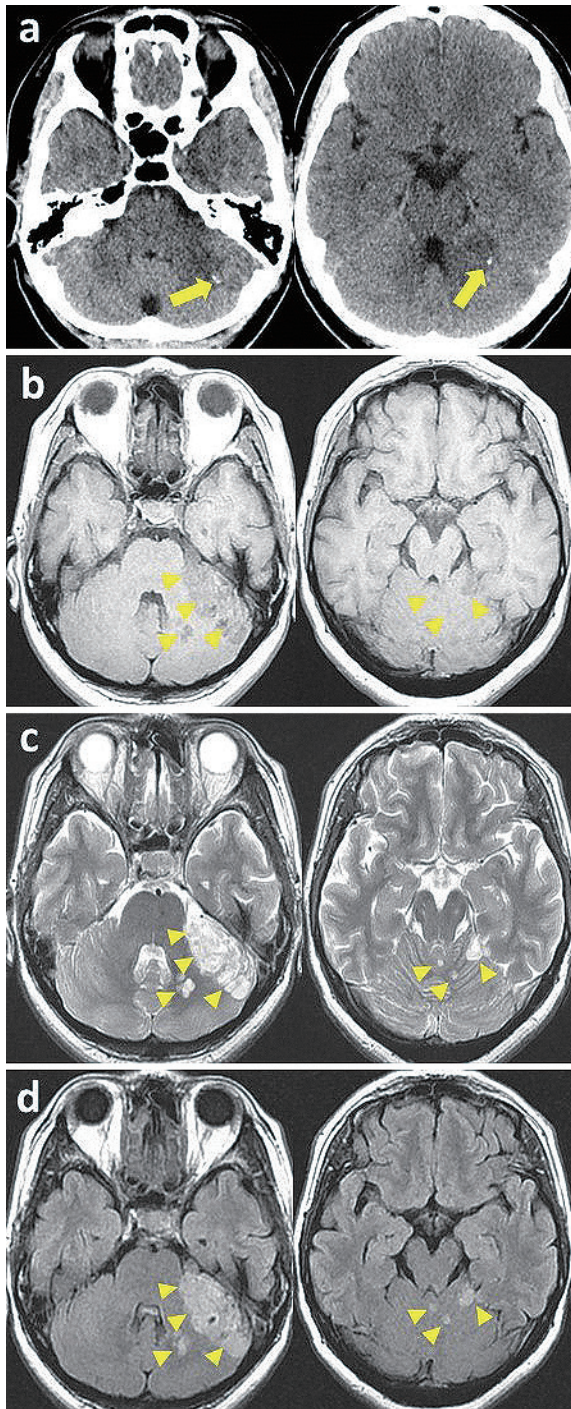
(a) Preoperative computed tomography (CT) scan showing a low-density area containing a focal calcified hyperdense lesion in the left cerebellar hemisphere (arrows). (b-d) Preoperative magnetic resonance imaging (MRI) scan showing multiple lesions in the left cerebellar hemisphere and vermis (arrowheads). (b) T1-weighted image showing hypointensity. (c) T2-weighted and (d) fluid-attenuated inversion recovery (FLAIR) image showing hyperintensity. Notably, there is no peri-tumoral edema or space-occupying effect.
